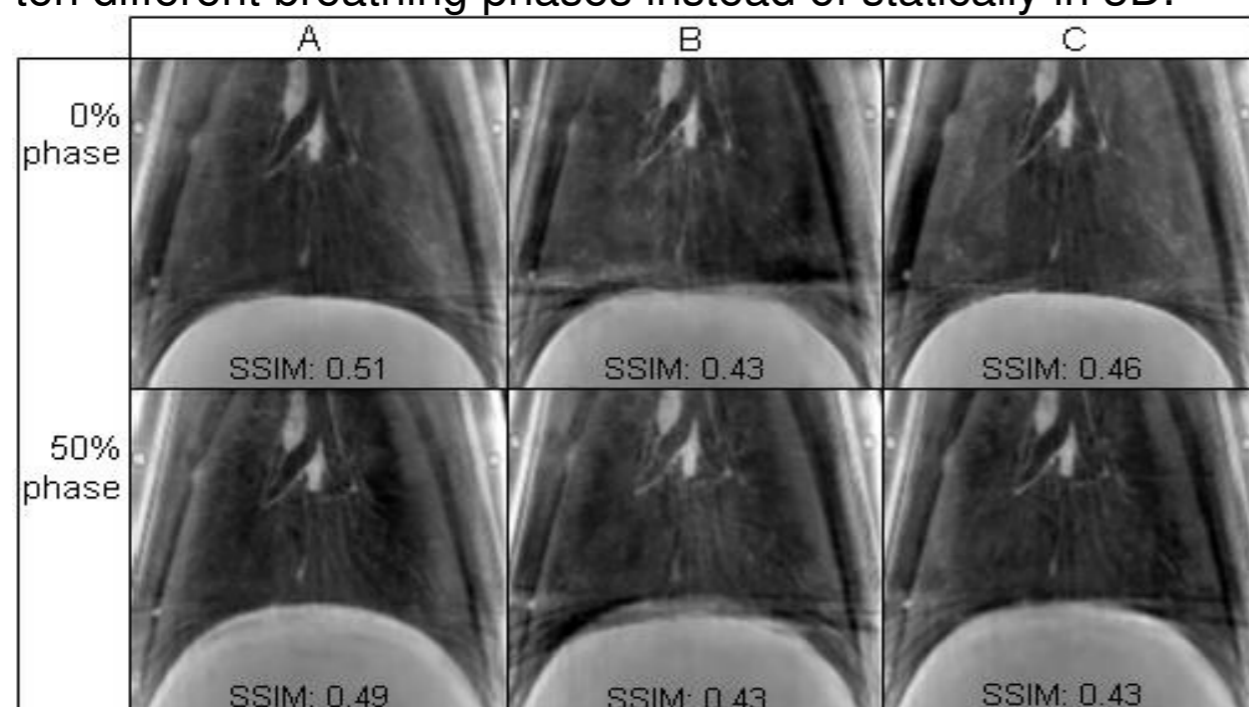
Coronal views with quality measure results for one of the 4DCBCTs (0% and 50% phases). The reconstructed diaphragms are compared for Amsterdam Shroud and Anzai signal projection binning methods.
